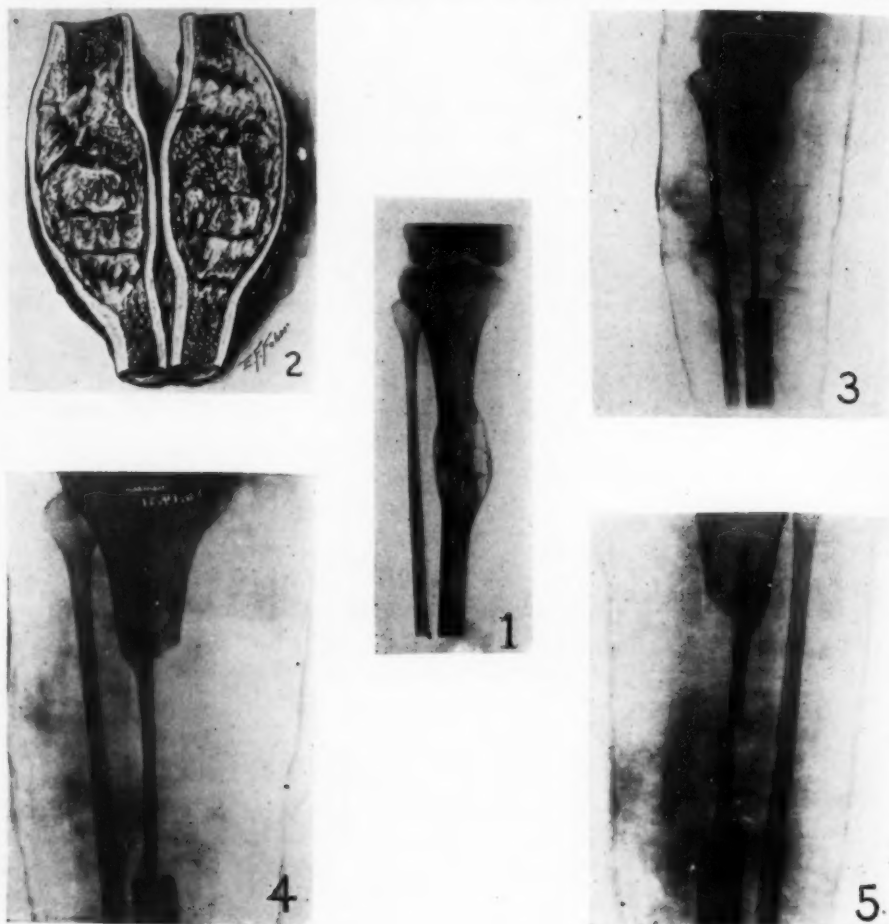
X-ray appearance of cyst.
